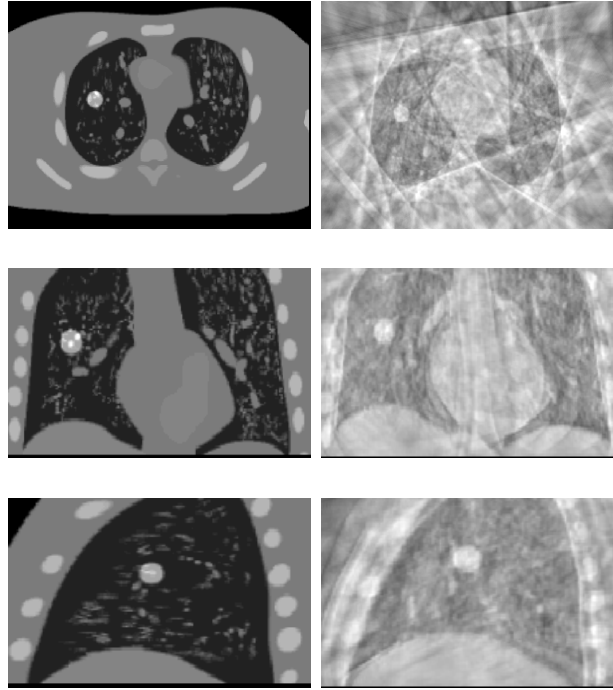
CBCT images reconstructed from NCAT CTs. Left: The axial, coronal and sagittal views of NCAT CT images. Right: The axial, coronal and sagittal views of NCAT CBCT images. The bright spherical object that can be seen from all three views is the tumor.
